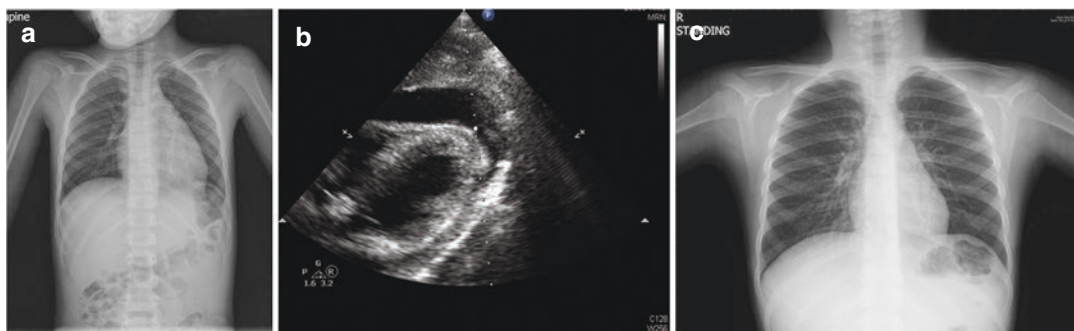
(a) Chest X-ray upon admission in a 7-year-old girl (case 1) with myopericarditis showed borderline cardiomegaly (cardiothoracic ratio [C/T ratio] 0.58). (b) Echocardiogram upon admission in a 7-year-old girl (case
